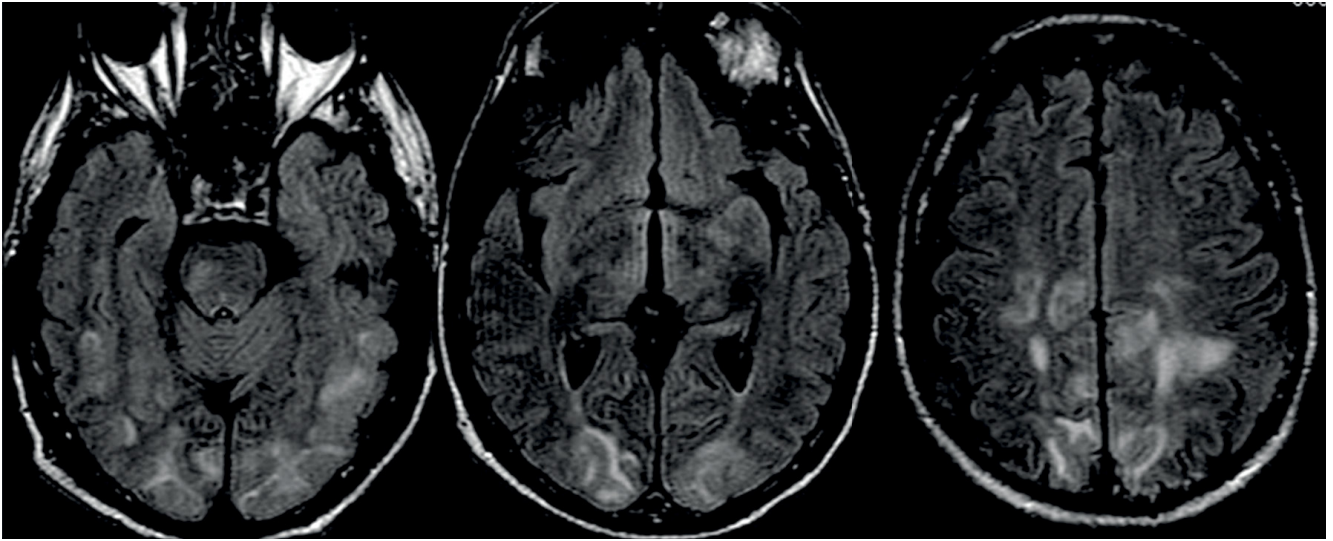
Patient with posterior reversible encephalopathy syndrome (PRES). The MRI demonstrates focal areas of symmetric brain edema with predominant involvement of posterior lobes.
